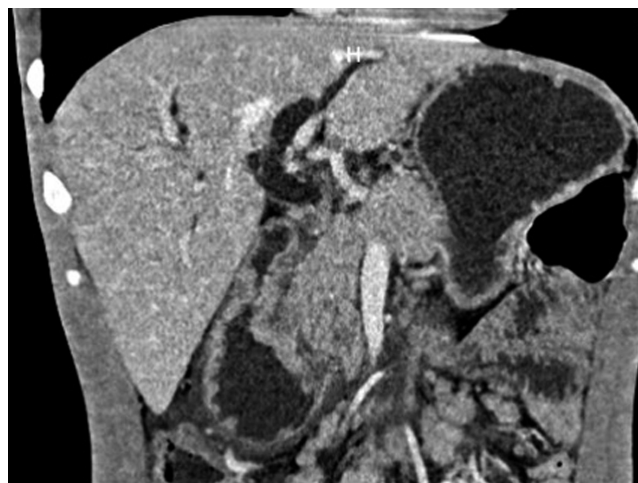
Simple and contrast-enhanced abdominal CT scan: dilation of the intra- and extrahepatic bile duct with a 14-millimeter common bile duct, the pancreas with slight dilation of the Wirsung duct, and loss of contours at the level of the head. The concentric circumferential wall thickened with enhancement after contrast administration and multiple mesenteric, retroperitoneal, latero-aortic, and intercaval-aortic lymphadenopathy in the periampullary region. Source: Radiology Department, Hospital Universitario del Valle.
